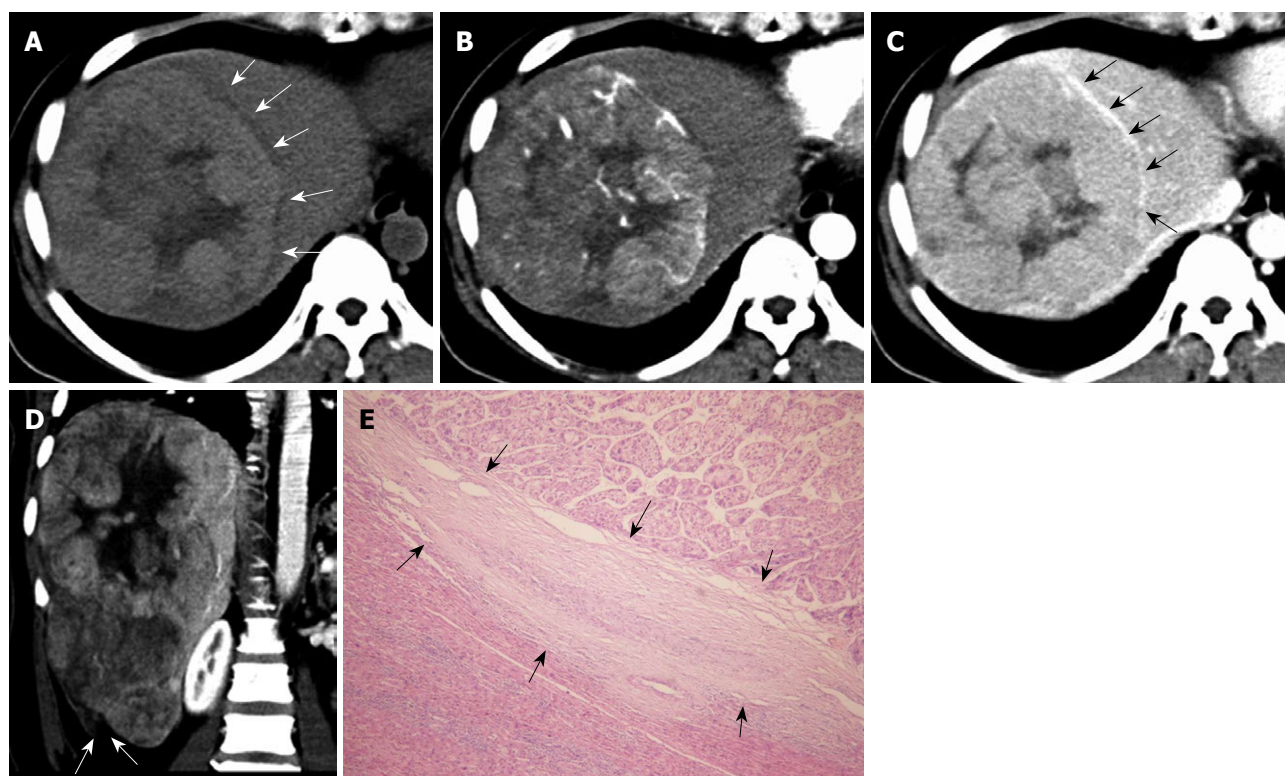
Primary clear cell carcinoma of the liver in a 47-year-old woman. A: On pre-contrast computed tomography scan, the mass shows slight hyper-attenuation with a hypo-attenuation halo (arrows); B: At hepatic arterial phase, the mass shows early enhancement; C: At the equilibrium phase, the mass presents hypo-attenuation with rim enhancement (arrows); D: At portal venous phase, the reconstructed coronal image shows the mass with a discontinuous liver capsule (arrows) at Segment VI, indicating tumor rupture, which was surgically confirmed; E: Pathologically, the mass shows a pseudocapsule (arrows) (HE, $\times 100$).
